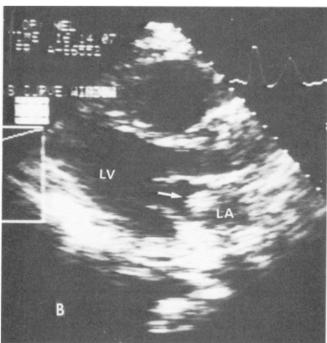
Conventional transthoracic two-dimensional echocardiogram. A, Four chamber view showing a mass (arrow) prolapsing through the tricuspid valve. B, Long-axis parasternal view showing a mass (arrow) within the left atrium (LA). LV = left ventricle; RA = right atrium; RV = right ventricle.
